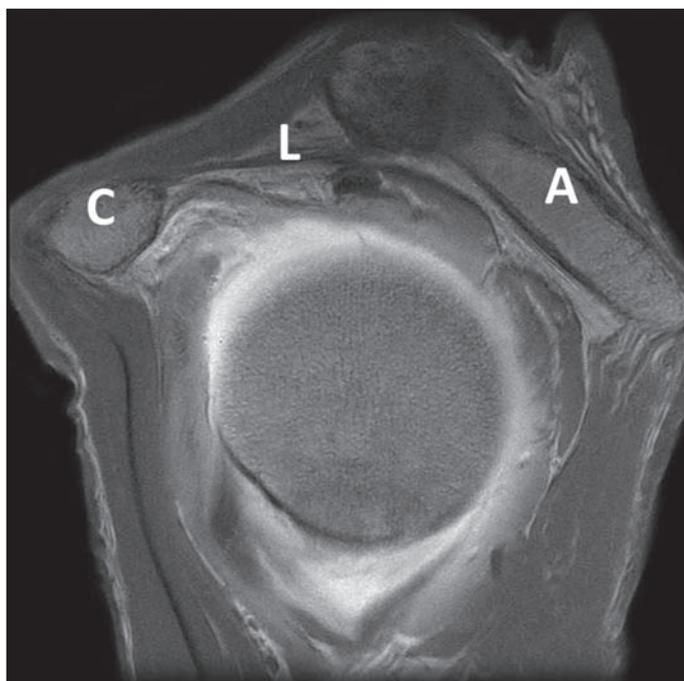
This sagittal-oblique slice MRI demonstrates the proximity of the acromion as part of the coracoacromial arch to the humeral head. The interposed tissues are at significant risk for impingement with overhead throwing activities. C = Coracoid, L = Coracoacromial Ligament, A = Acromion.
